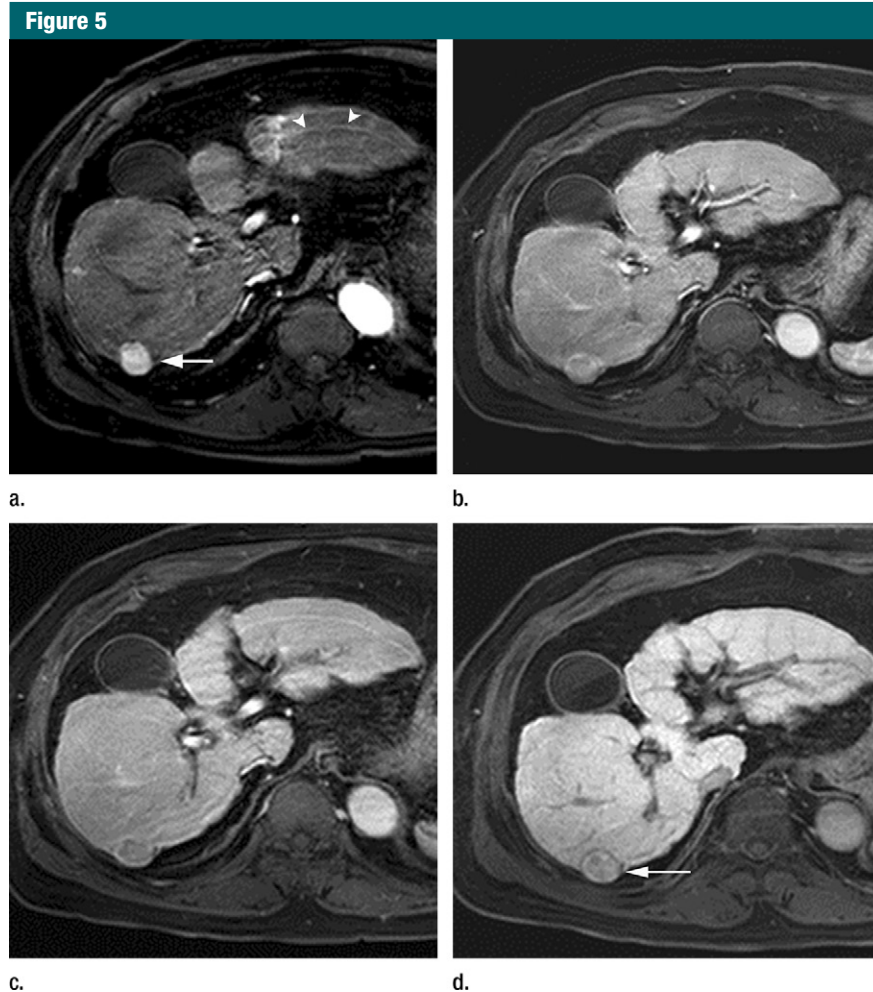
MR images in a 70-year-old man with HCC show hyperintensity in the hepatobiliary phase. (a) Gadoxetate disodium–enhanced T1-weighted 3D GRE image (2.5/0.9; 11° flip angle) in late hepatic arterial phase shows hyperenhancing mass (arrow) in right posterior liver. (b, c) Relative to liver, mass is slightly hyperintense in (b) portal venous phase and mildly hypointense in (c) transitional phase. (d) In the hepatobiliary phase, mass is hyperintense with hypointense rim, likely representing tumor capsule (arrow). Presence of hypointense rim permits confident diagnosis of HCC despite hyperintensity of lesion. Note motion artifact on arterial phase image (arrowheads).
